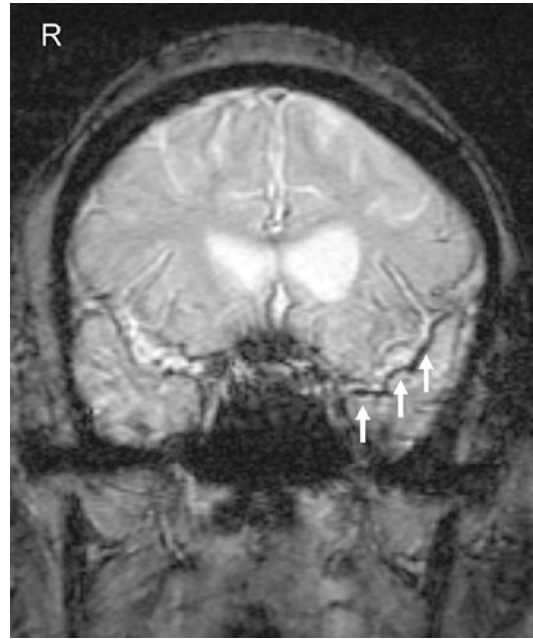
Chronic SAH on GRE MRI. Coronal GRE T2*-weighted image demonstrates bilateral decrease in signal within the temporal sulci, with the greatest accumulation within the left Sylvian sulcus (*arrow*) due to hemosiderin deposits (superficial siderosis)
